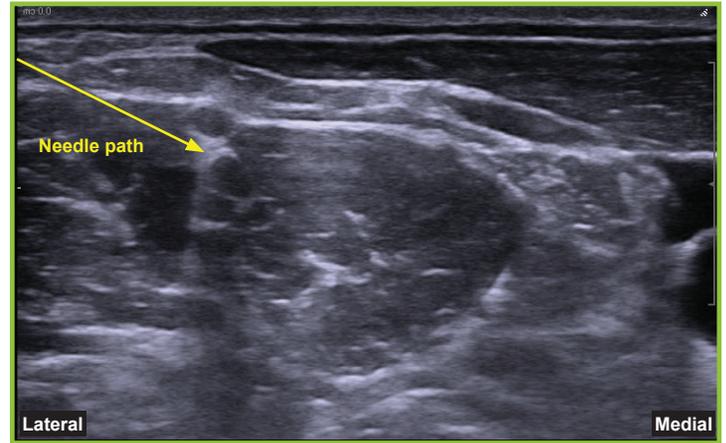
Interscalene brachial plexus nerve block ultrasound
